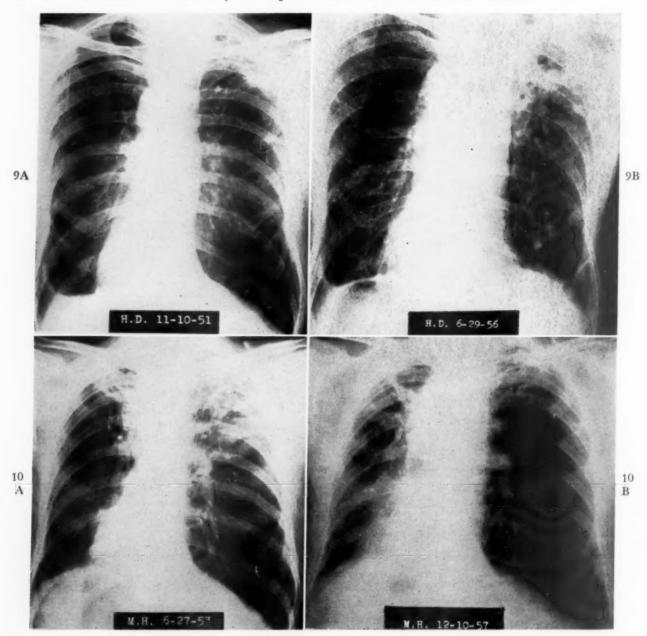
Case v. A and B, chest roentgenograms taken approximately four years and seven months apart showing enlargement of the right apical lesion and increase in size of the cavity.
